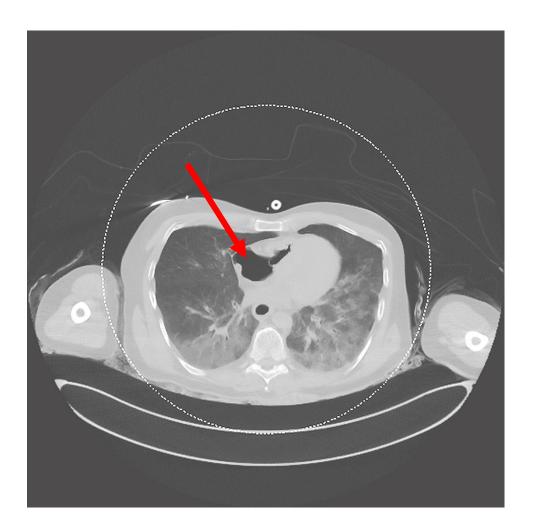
CT Scan of the intracardiac region showing gas sampled in the right ventricle (red arrow).
